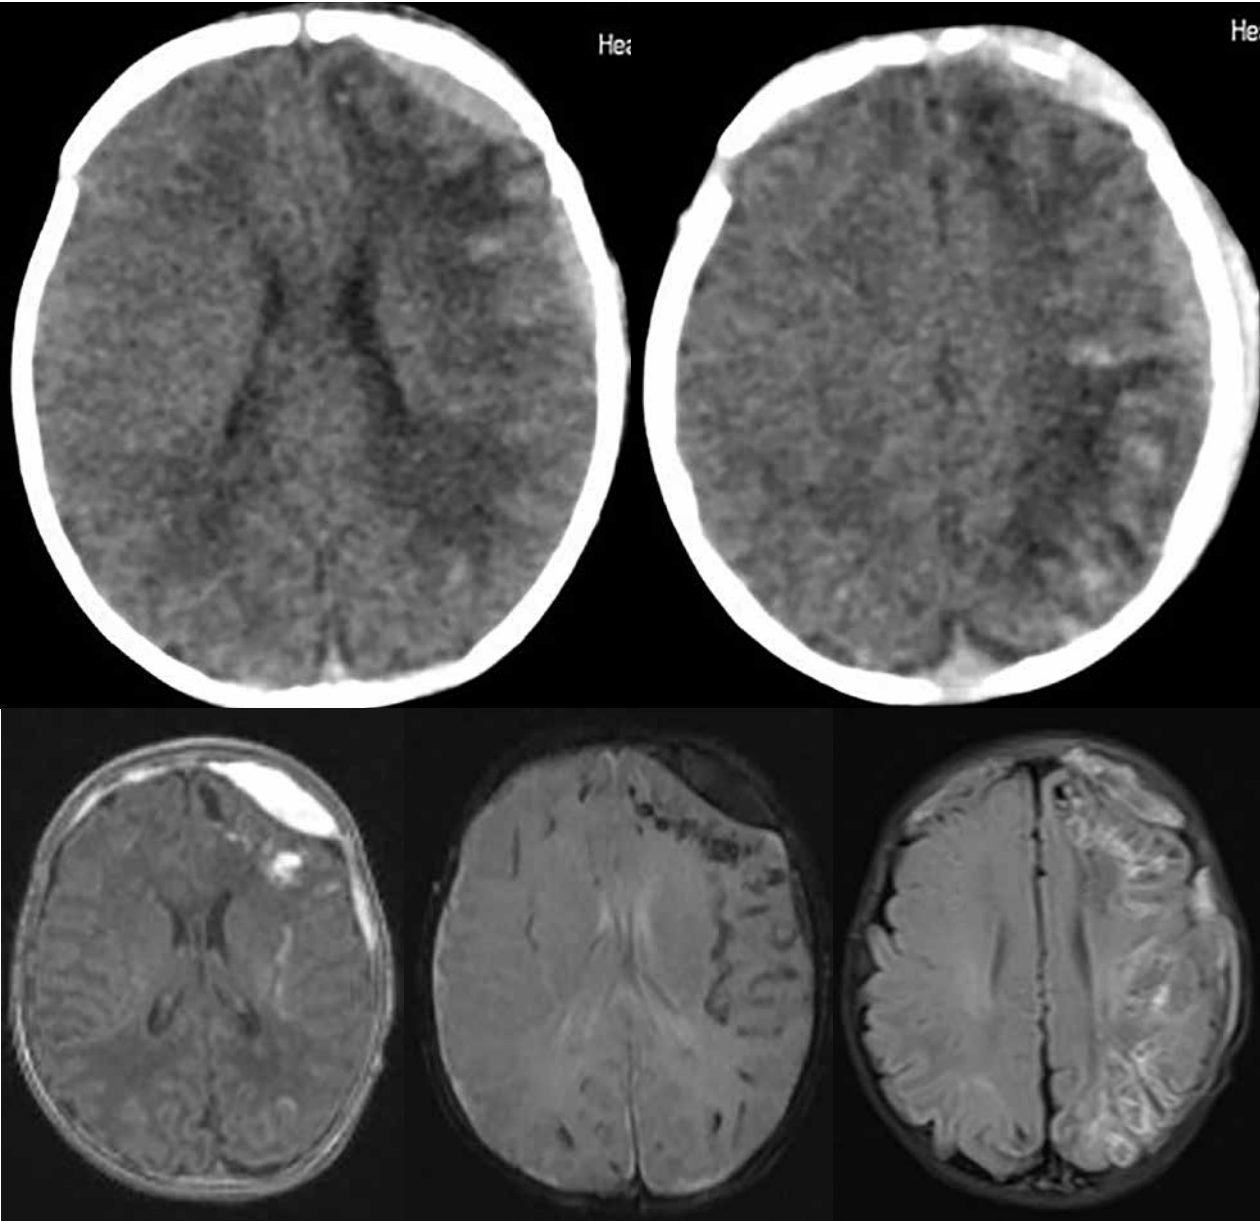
Sturge-Weber syndrome with an acute epidural haematoma at the left frontal lobe as a concomitant pathology (a, b – axial CT; axial MRI: c - T1W; d - T2W fl2d hemo; e - T2W FLAIR).
